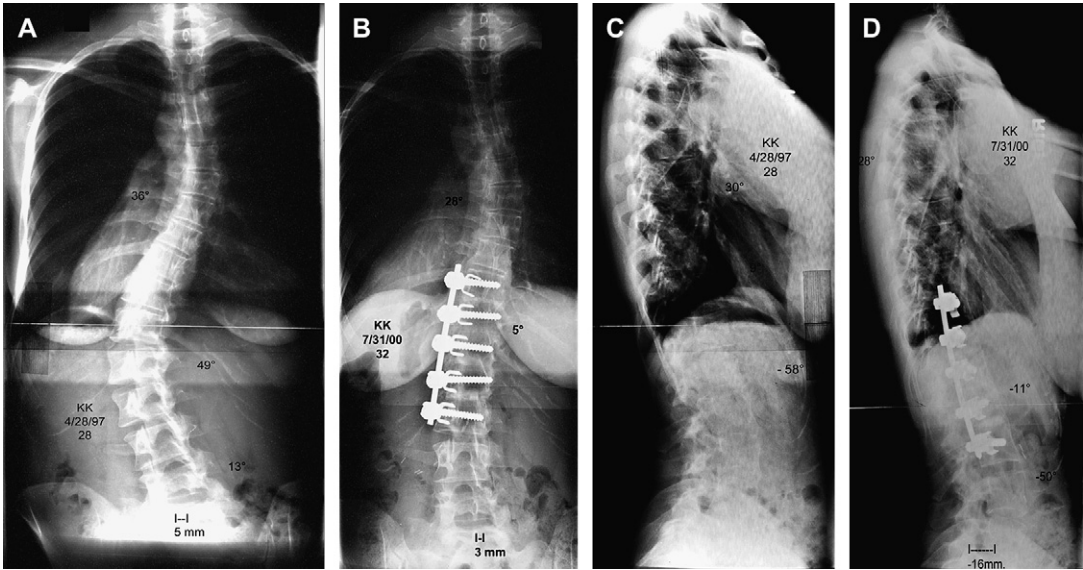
Preoperative (A–C) and postoperative (B, D) radiographs of a 28-year-old woman with adult thoracolumbar scoliosis treated with anterior instrumented fusion.
